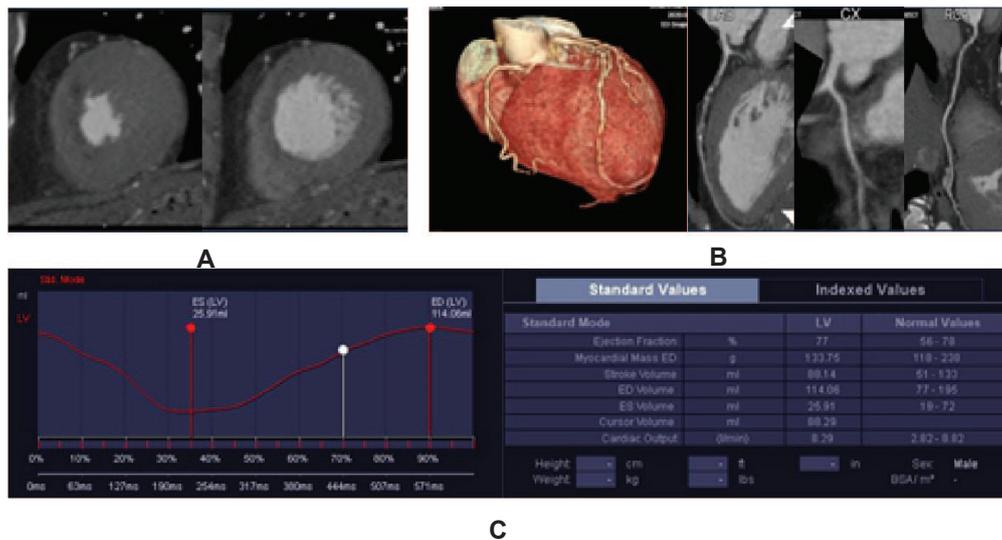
A Short axis planes of the heart by cardiac CT in systole and diastole phases. B.VRT and MIP outline coronary artery: LAD, LCX, RCA. C. Automate mesuerement by software : EF, EDV, ESV.
